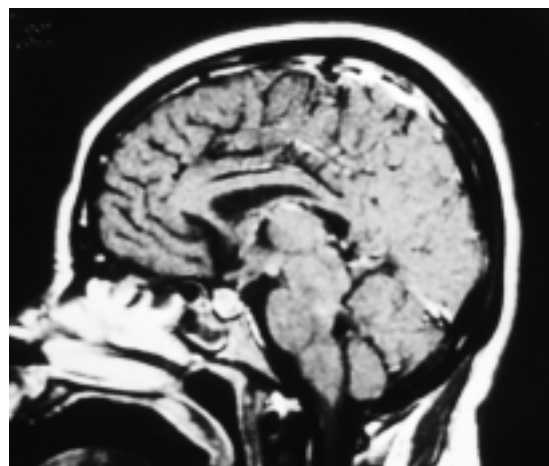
AWE. MRI sagittal T1 gadolinium enhanced image: hyperintensities in diencephalon and brainstem (see text for description).
